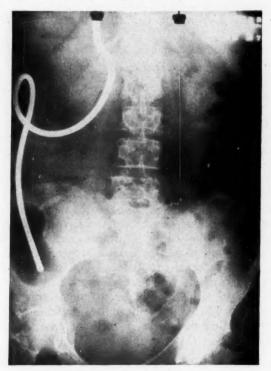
X-ray film taken one hour after evident movement of the tip of the Miller-Abbott tube had begun. It shows the tip in the sigmoid
